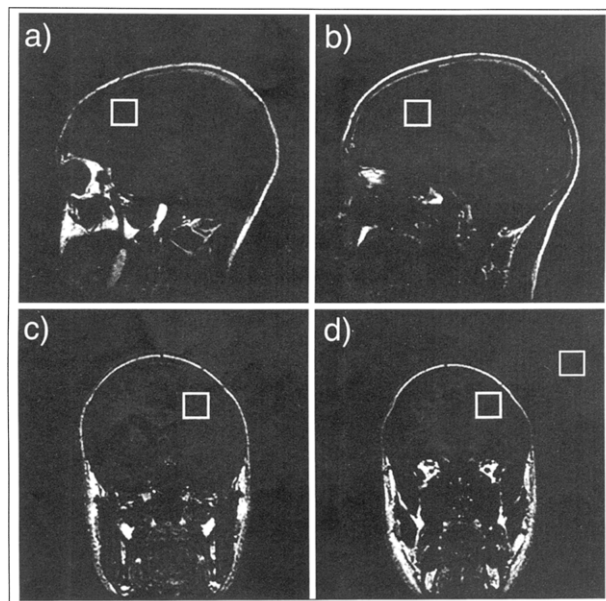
The white box represents the location of the volume of interest ($2 \times 2 \times 2 \text{ cc}$) in the left dorso-lateral prefrontal cortex. Sagittal (a and b) and coronal (c and d) magnetic resonance images are presented.
